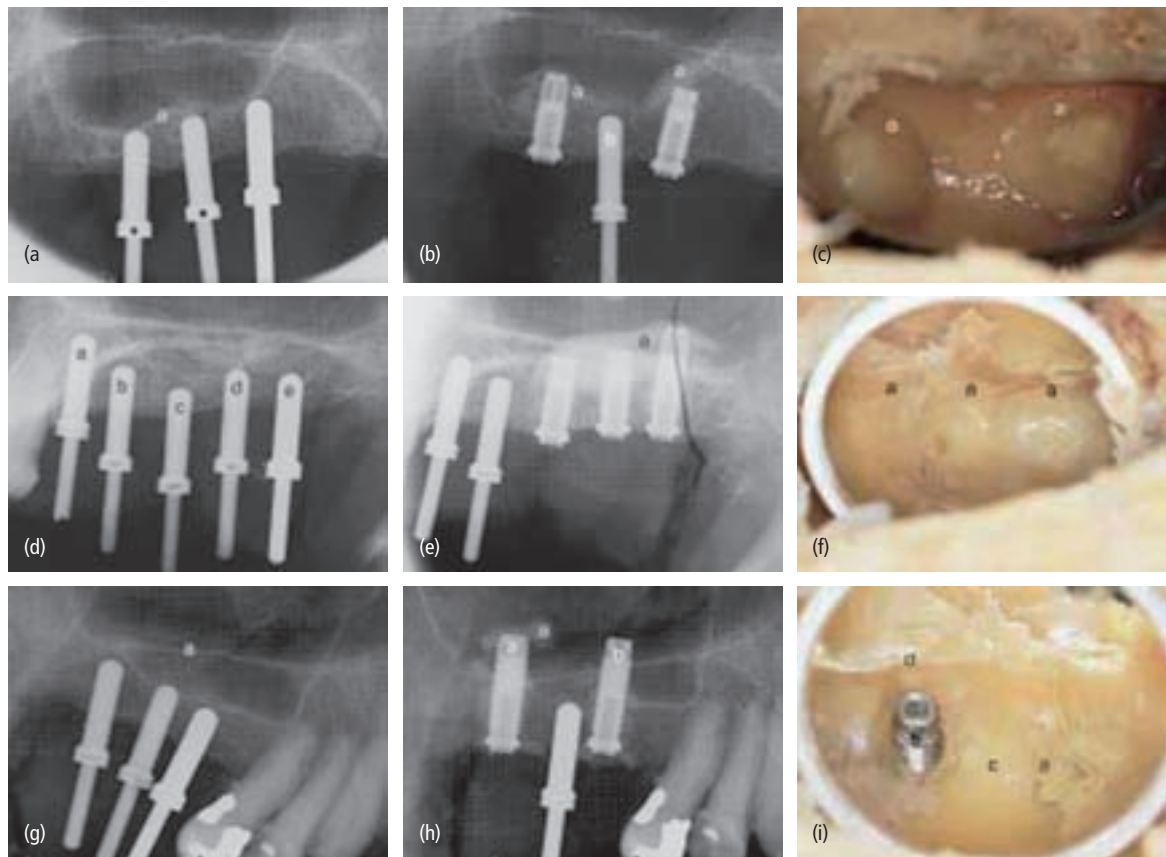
(a) Three radiopaque indicators in place within 1 mm of the sinus floor *a*. (b) Implant placement following osteotome technique provided so as to elevate the maxillary sinus membrane. Notice the radiopaque material surrounding the implants *a* in comparison to the control site *b*. (c) Dome-shaped elevation of the maxillary sinus membrane demonstrated by intrasinus photography achieved by careful dissection of the lateral wall of the nose and placement of an intraoral mirror at the middle third of the sinus. No perforation was present. Notice the moist sinus. Intact dome-shaped elevations *a* are clearly demonstrated. (d–f) Multiple implant placement with the osteotome technique. (d) Radiographic presentation of orientation drill *a*, control site *b*, and test sites *c–e*. (e) The same region after sinus elevation and implant placement. Notice that the radiopaque material around the implants is contained with no indication of perforation *a*. (f) Continuous doming of the maxillary sinus membrane *a*. This documentation demonstrates that contiguous doming can be successfully achieved using the crestal osteotome technique. (g) Three radiopaque indicators in place; the middle serving as a control. Notice the nasal floor *a*. (h) Implants in place. Notice the partial loss of containment of the radiopaque material around the distal implant *a* and the lack of radiopaque material around the mesial implant *b*. (i) Demonstration of a class I perforation *a*, and a class II perforation *b*, adjacent to an incomplete septum *c*, located at the floor of the sinus. Proximity to the collateral nasal wall *d* can also be noted. Class I perforation is shown around the distal implant *a*. The dome-shaped elevation is still maintained by the implant. It is possible, in a clinical situation, for the remaining graft and blood clot to serve as a vital scaffold, allowing spontaneous healing of the membrane. The prognosis for such an implant *in vivo* is considered favorable. Class II perforation is shown around the mesial implant *b*. Loss of the dome-shaped elevation and implant protrusion to the sinus space are noted. The prognosis for such an implant *in vivo* is considered guarded. (Reproduced with permission from Reiser *et al.* (43). © Quintessence Publishing Co.)
